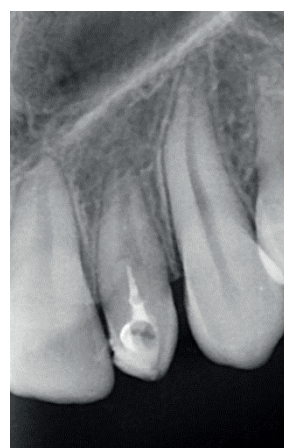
Control periapical radiograph after filling the invagination
